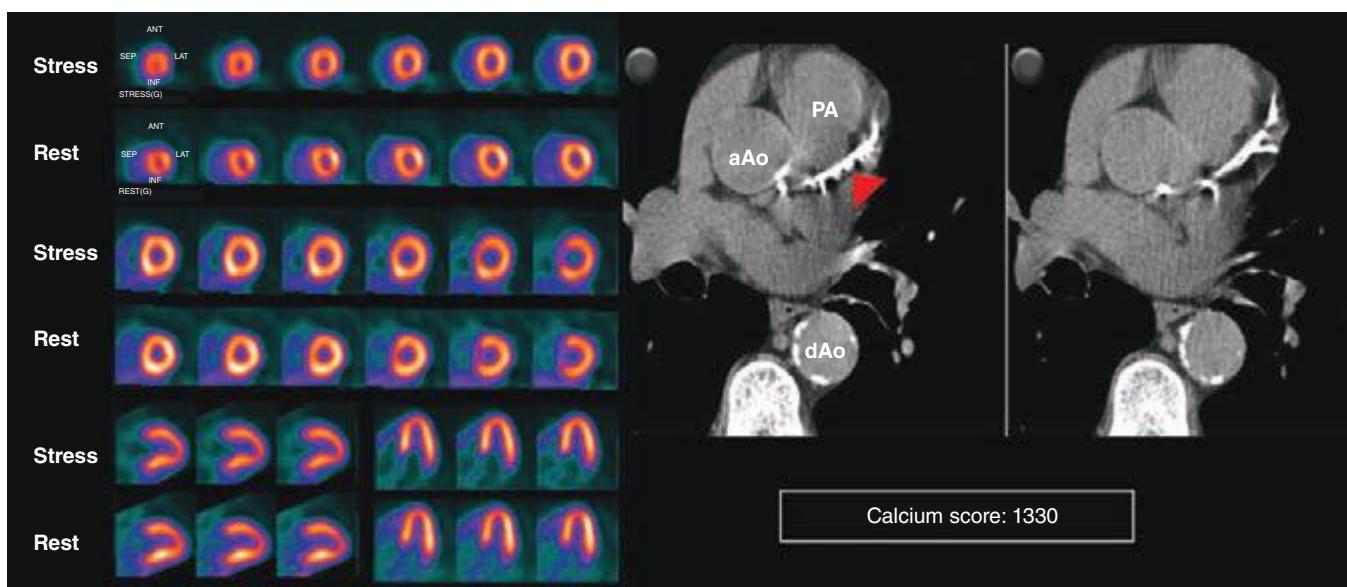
11 Stress and rest rubidium-82 myocardial perfusion positron emission tomography (PET) images (left) and noncontrast gated computed tomography (CT) images (right) delineating the extent and severity of coronary artery calcifications obtained with integrated PET/CT imaging. The images demonstrate extensive atherosclerosis (Agatston coronary calcium score = 1330) without flow-limiting disease based on the normal perfusion study. aAo, ascending aorta; dAo, descending aorta; PA, pulmonary artery.
